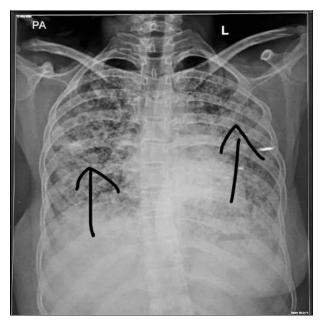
Pre-intervention chest X-ray in PA view. The black arrow points at prominent bronchovesicular marking
